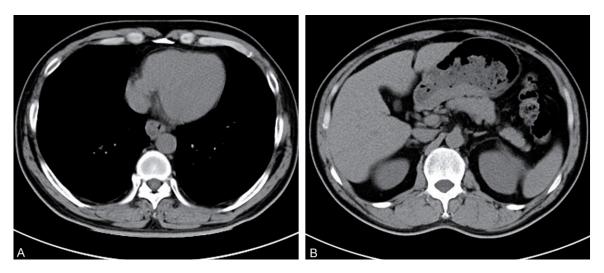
A. Computed tomography of the chest showed thickening of the lower third of the esophageal wall. B. Computed tomography of the abdomen showed malignant lesions in the antrum in the distal part of the stomach.
